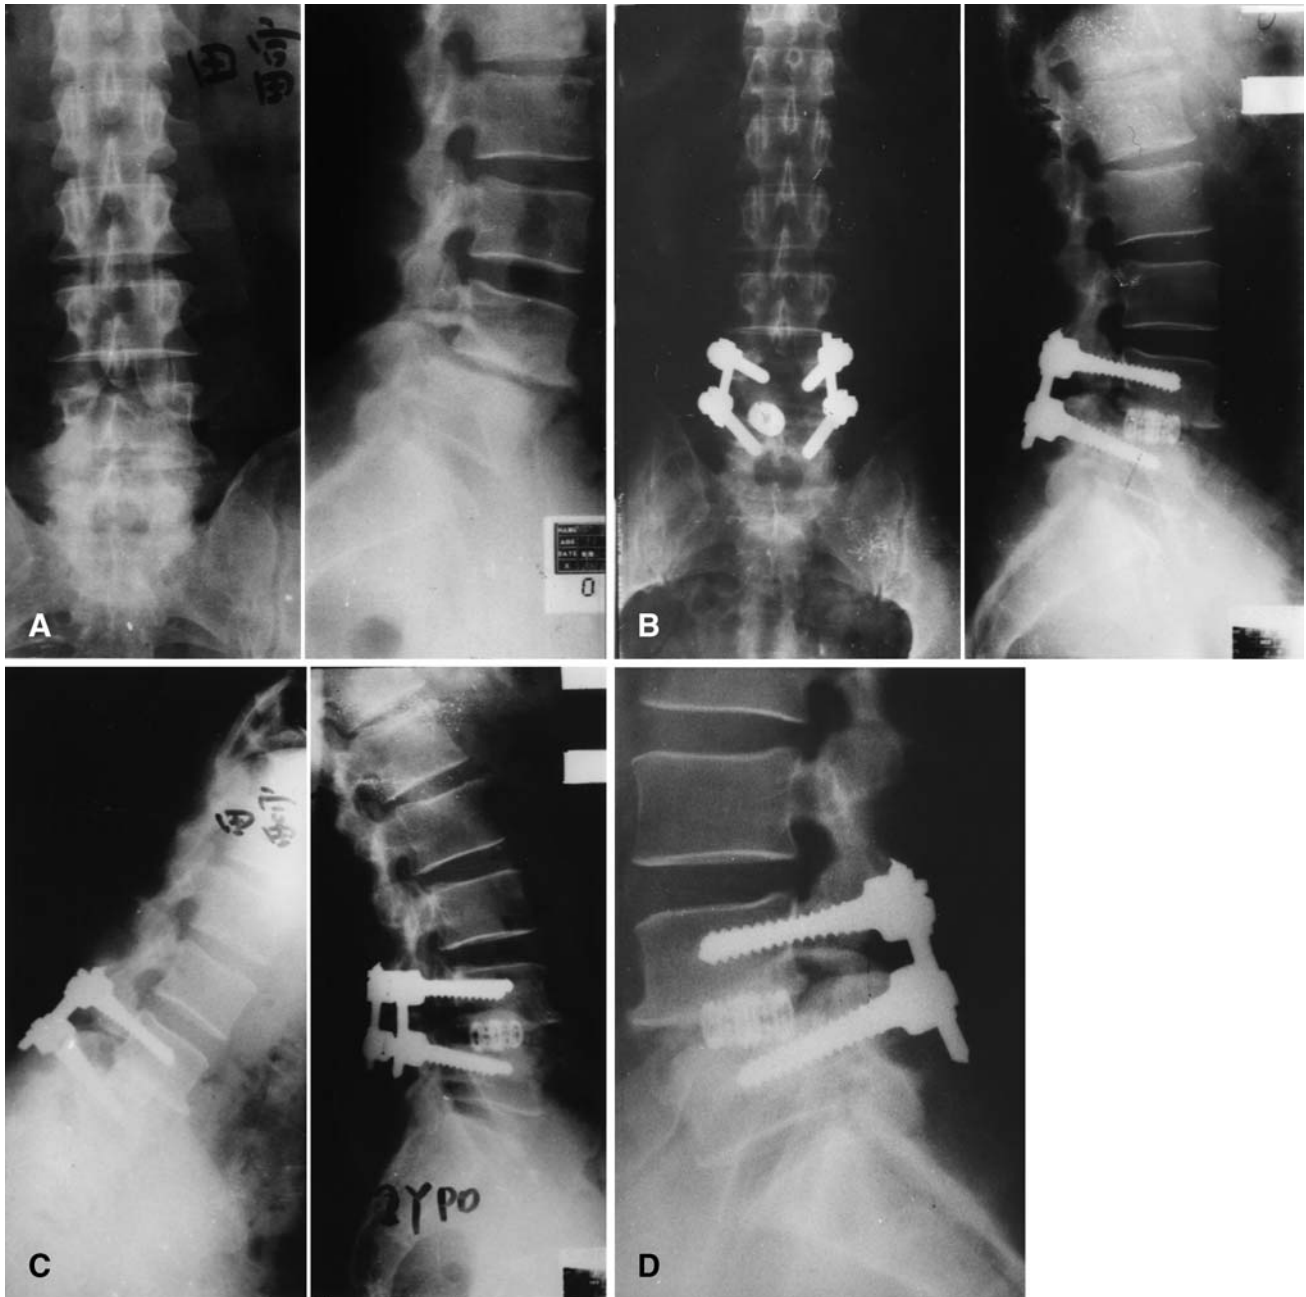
A A 41-year-old man with symptomatic grade 1 isthmic spondylolisthesis. B He was treated with posterior lumbar interbody fusion (PLIF) using one diagonal BAK cage with unilateral facetectomy and with transpedicular screw fixation. C The result at 2-year follow-up. D The lateral radiograph at 2-year follow-up showed bony trabeculae bridging the fusion level
